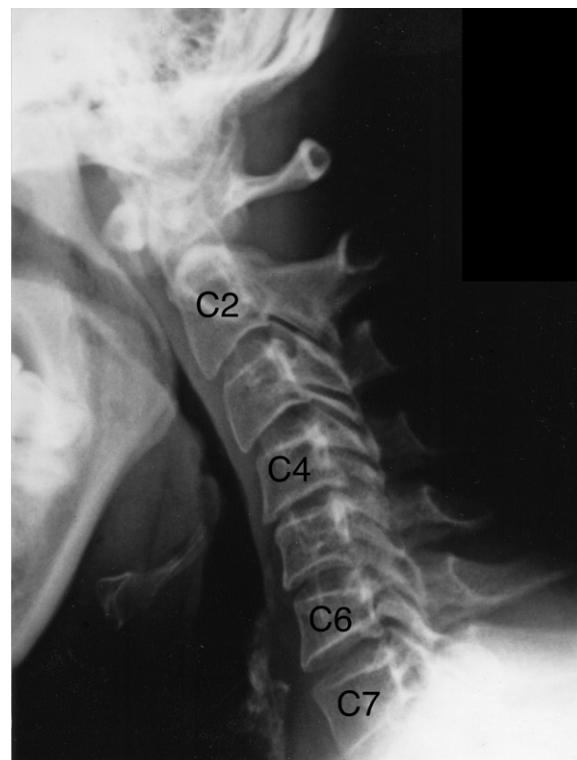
Cervical spine flexion plain X-ray image. Note the loss of normal cervical spine contour with restricted movement below the C4 level.
